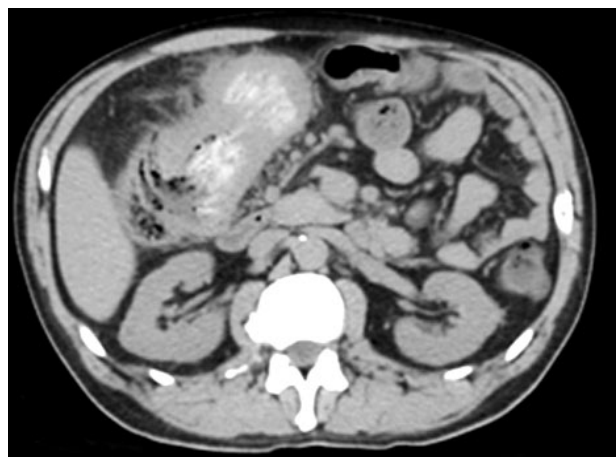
CT scan showing a 10cm tumor of the right colon, located at the hepatic angle.
